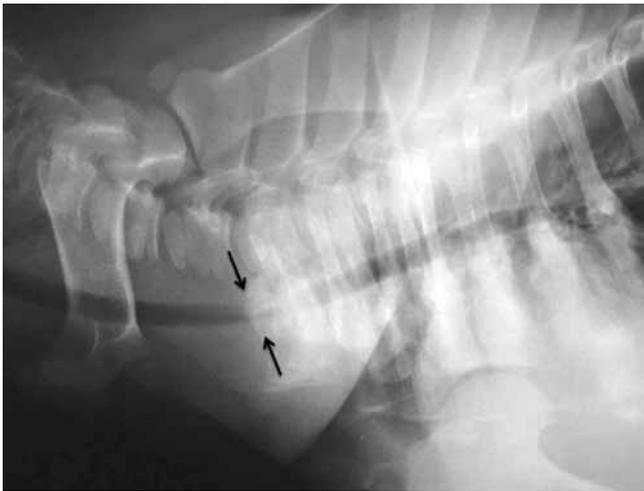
The lateral thoracic radiograph area of the calf with tracheal collapse and the narrowing of the tracheal diameter at the thoracic inlet (black arrows).
